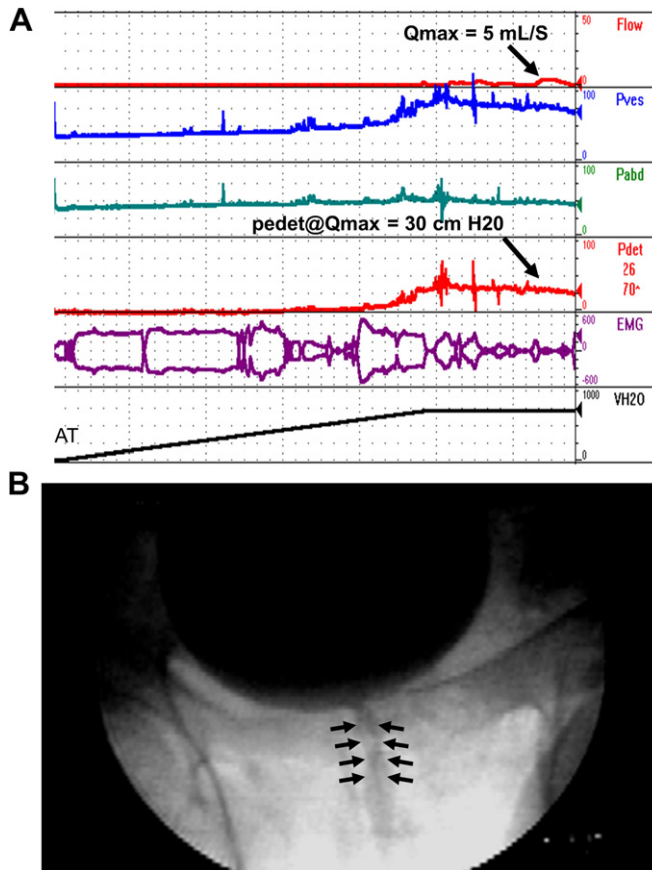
Impaired detrusor contractility in a 58-year-old man who complained of urinary frequency, urgency, occasional urge incontinence, hesitancy, and a weak stream. A. Urodynamic study: first sensation of filling (FSF) = 272 mL; first urge = 491 mL; severe urge = 620 mL; bladder capacity = 710 mL; Q_{\max} = 6 mL/s; $P_{\det@Q_{\max}}$ = 28 cmH₂O; $p_{\det\max}$ = 41 cmH₂O; bladder outlet obstruction index = 16; Schaefer grade 1, W. Although results of this study fall far short of qualifying as urethral obstruction based on urodynamic criteria, the fact that he had a sustained detrusor contraction and diffuse narrowing of the prostatic urethra suggests prostatic obstruction as well as impaired detrusor contractility. B. X-ray obtained at Q_{\max} showing a narrowed prostatic urethra (arrows). This patient underwent transurethral resection of the prostate and had a very successful outcome.
